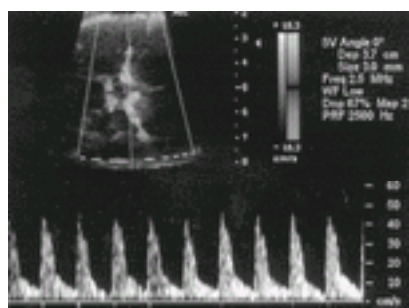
The ultrasound color Doppler image shows the circle of Willis and the middle cerebral artery branches. Also shown is the near 0-degree angle of insonation and the middle cerebral artery flow velocity waveform. See [color figure 12.4](#).
